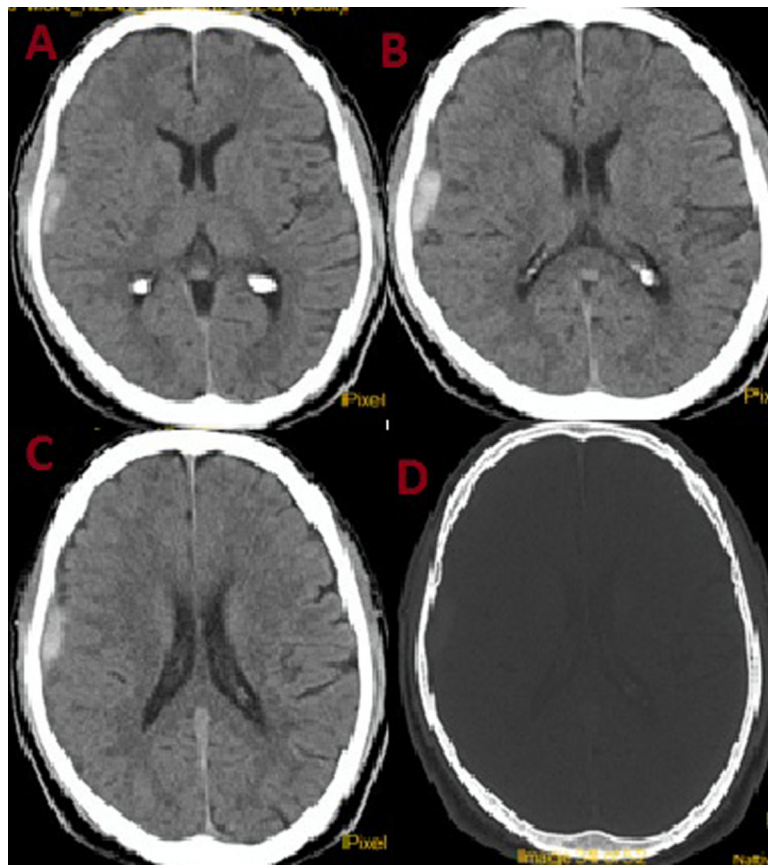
CT head plain axial view. (A–C) A right temporoparietal acute subdural hematoma, mild mass effect with effacement of sulci and (D) intact calvaria on bone windows.
